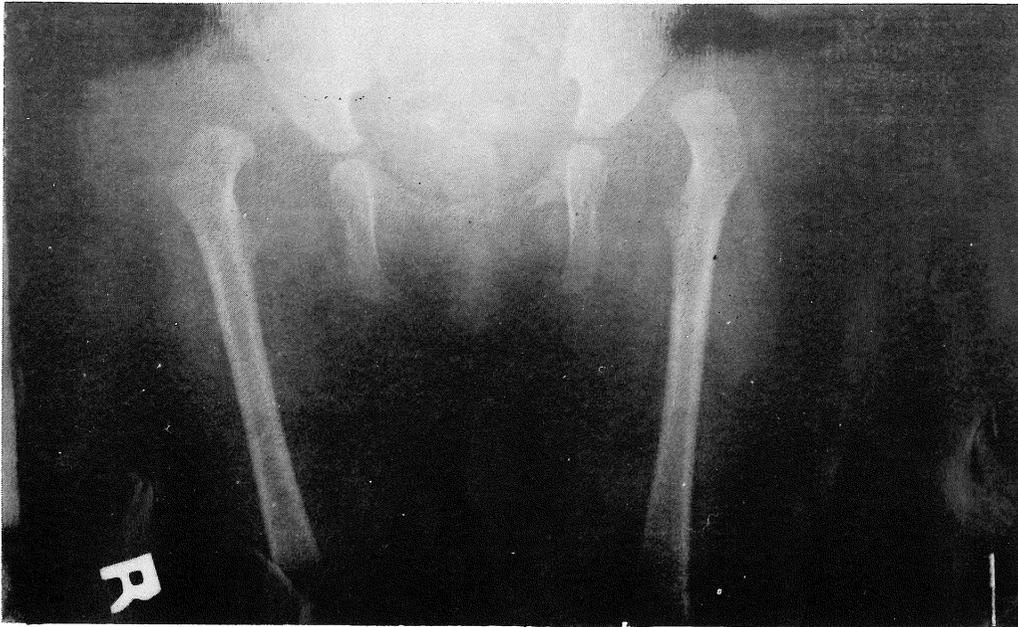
Radiograph of one year old boy with bilateral CDH.
